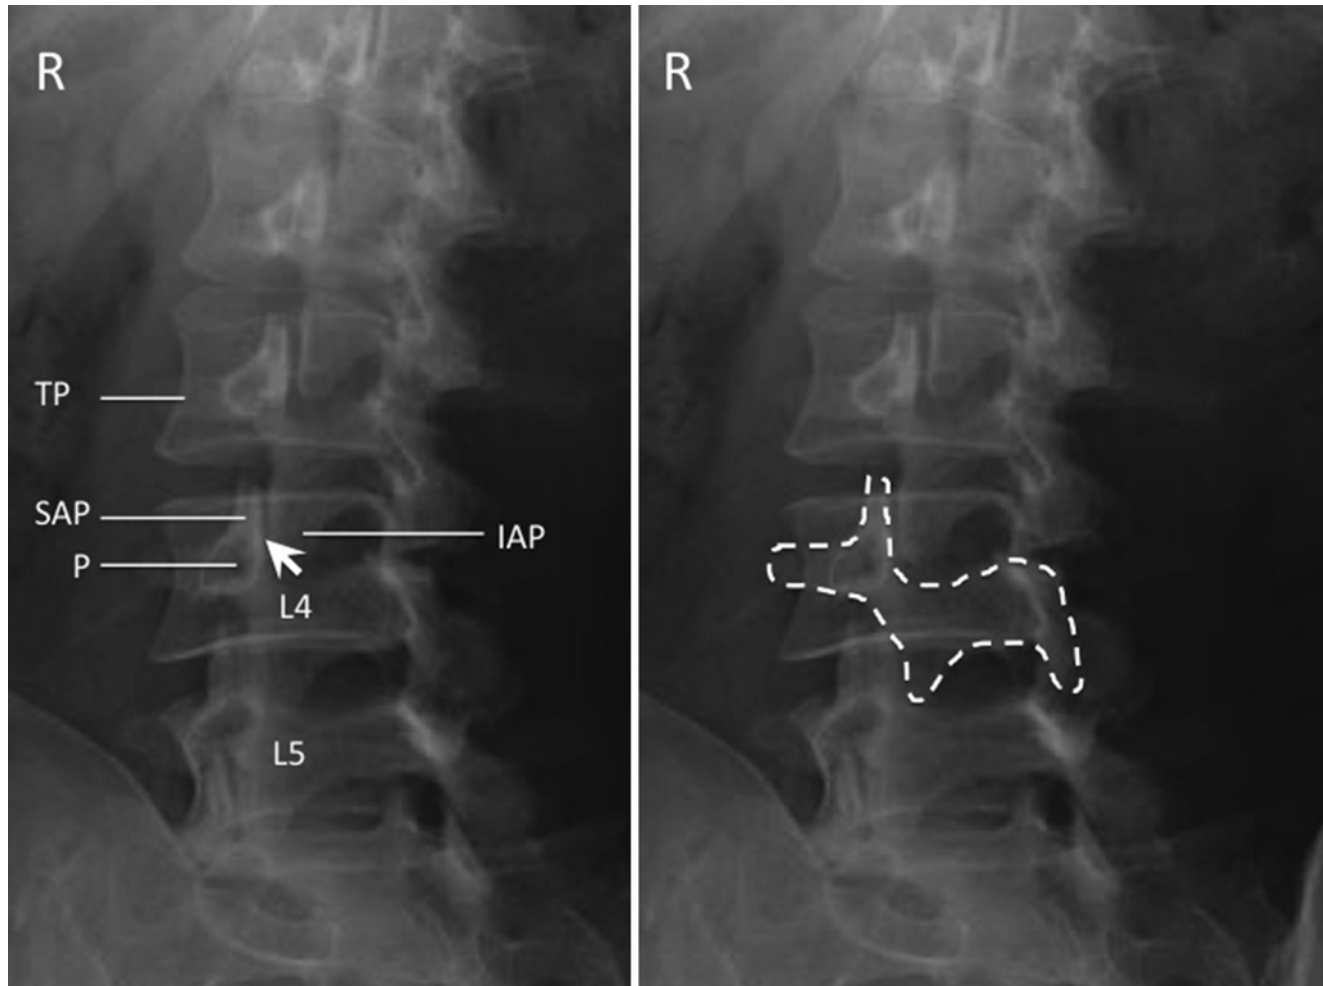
Oblique radiograph of the lumbar spine. The *left figure* shows the individual structures: *SAP* superior articular process, *IAP* inferior articular process, *P* pedicle, *TP* transverse process; facet joint is
